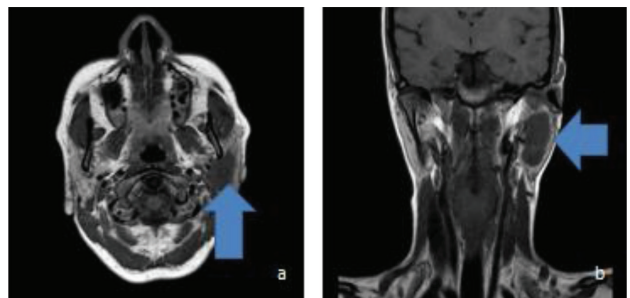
Magnetic resonance images. (a) T1WI axial section shows a well-defined hypointense lesion near the angle of the left mandible (vertical arrow). (b) T1WI coronal section shows the superoinferior extent of hypointense lesion (horizontal arrow).
